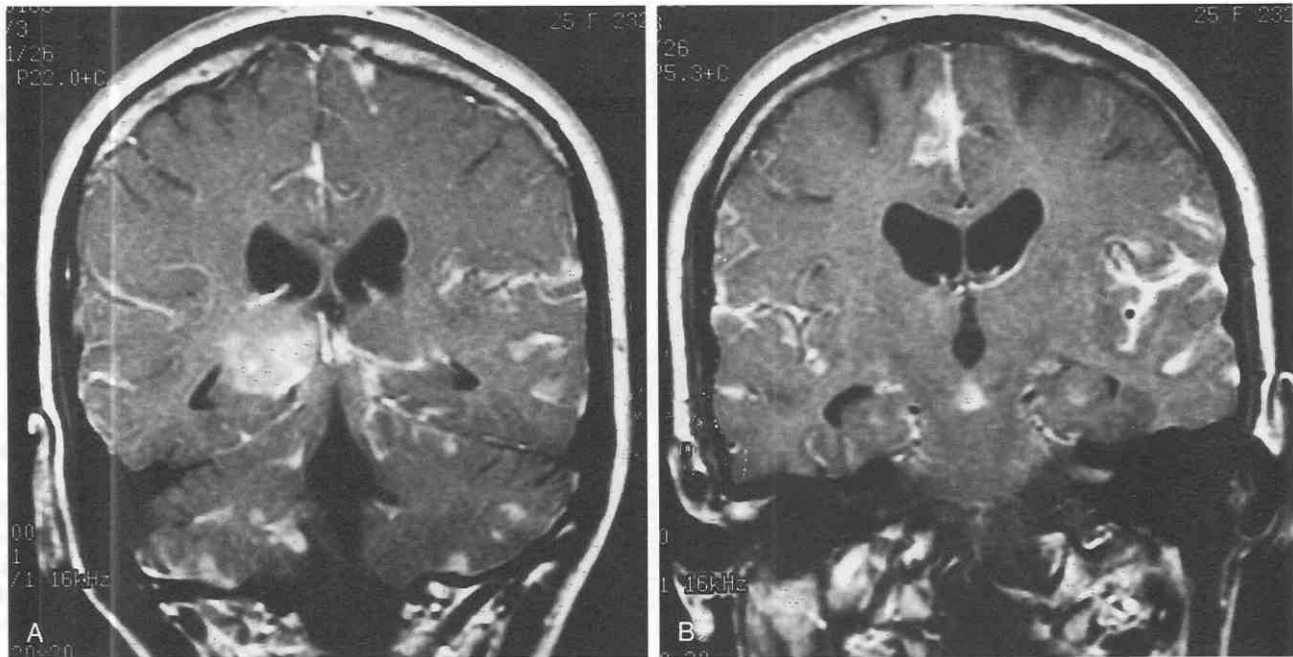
Cerebrospinal fluid spread of glioblastoma multiforme after biopsy in a 40-year-old patient. Six weeks after stereotactic biopsy, an enhanced coronal T1-weighted image shows the primary right thalamic glioblastoma and extensive, thick dissemination of neoplasm in a pia/subarachnoid space pattern.
